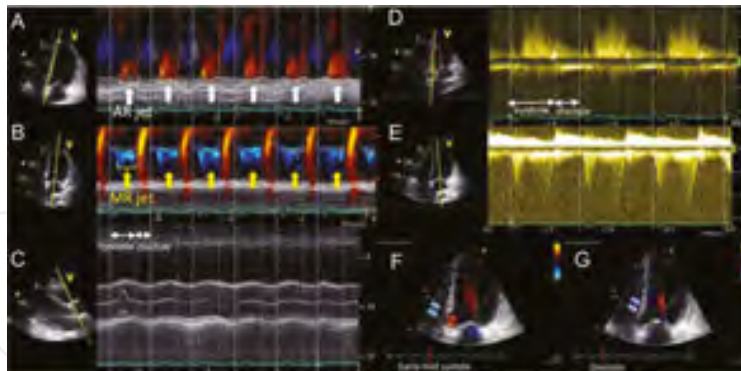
Aortic regurgitation during systolic phase accompanied by mitral regurgitation in patients with a continuous-flow left ventricular assist device (quoted from Ref. [22]). Echo images obtained from a patient undergoing LVAD implantation who showed systolic-phase aortic regurgitation (AR). The timing of the regurgitation jet started at the mid-systolic phase and ended at the early diastolic phase (A). The AR occurred slightly after the onset of mitral regurgitation (MR) (B), and both MR and AR timings were consistent with the systolic phase. No remarkable AR jet was documented during the diastolic phase. The AV was mostly closed throughout the cycles, which opens once every 8–10 beats (C). The mean pressure gradients of the trans-AV and trans-mitral valve based on the continuous wave Doppler measurements of AR (D) and MR flow (E) were 3.7 and 24.3 mmHg, respectively. The morphology of AV annulus changes through the cycles irrespective of the AV opening, with the AV annulus abnormally distorted and dilated during early mid-systole (F), whereas the septum wall as well as the AV annulus edge slightly pushed toward the LV during diastole (G).
